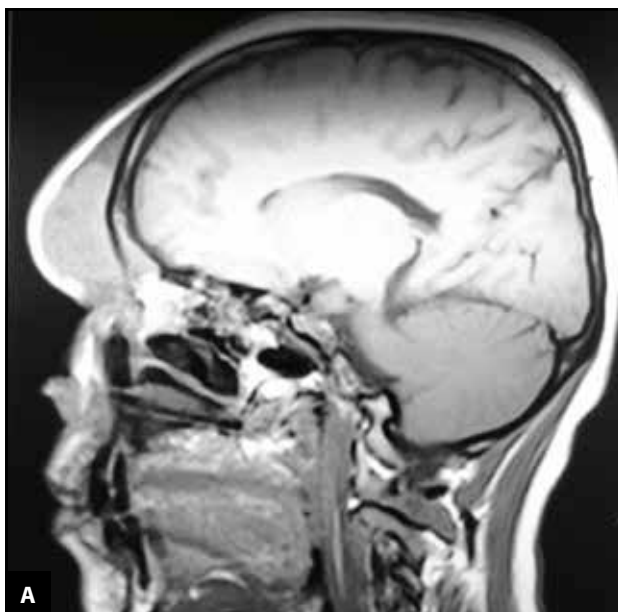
Cerebral MRI with intravenous contrast (A. Sagittal view, B. Axial view) showing a soft tissue mass in the frontal scalp, eroding the outer edge of the frontal sinus.
